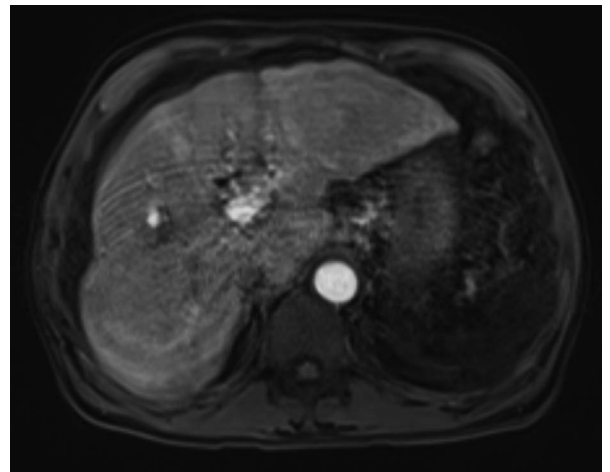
Liver. MRI. T1 weighted. Fat suppression. Contrast enhancement. Arterial phase. Axial plane.
